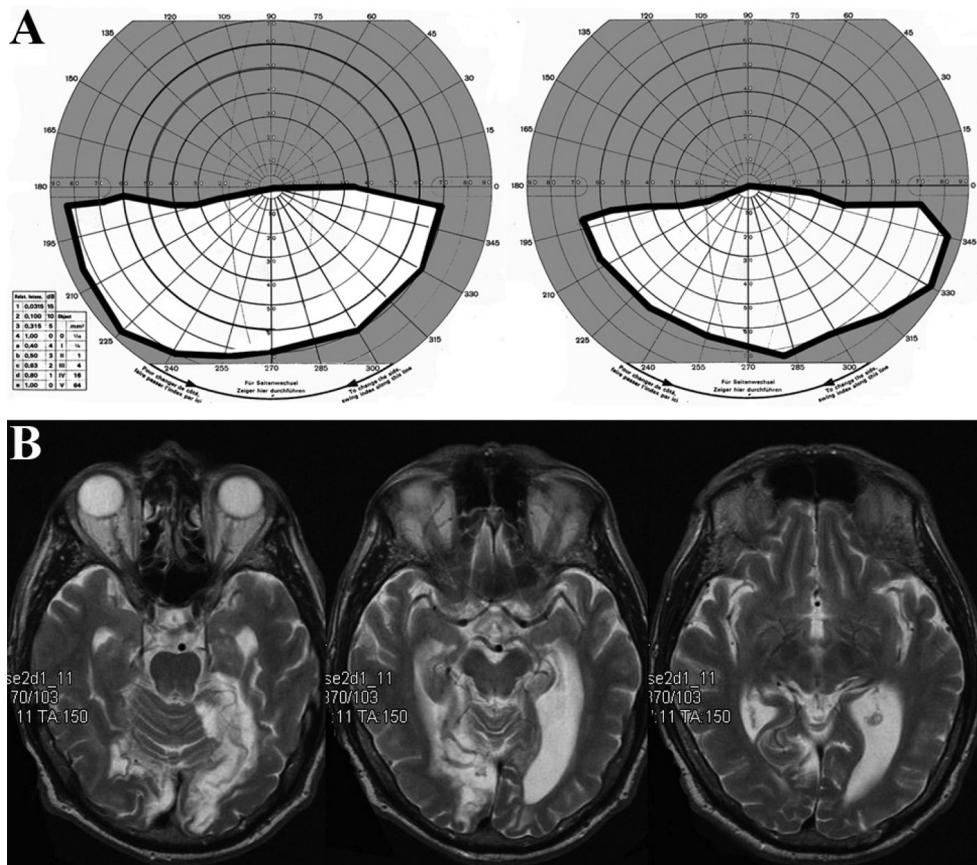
Visual field assessment. A. The Goldmann perimetry showed superior, congruent, and bilateral superior altitudinal hemianopia with partial involvement of the macular vision; B. Axial T2-weighted images showed bilateral, almost symmetrical, chronic ischemic lesions, which are located in the occipito-temporal regions under the calcarine fissure, in the superficial territory of posterior cerebral arteries.
